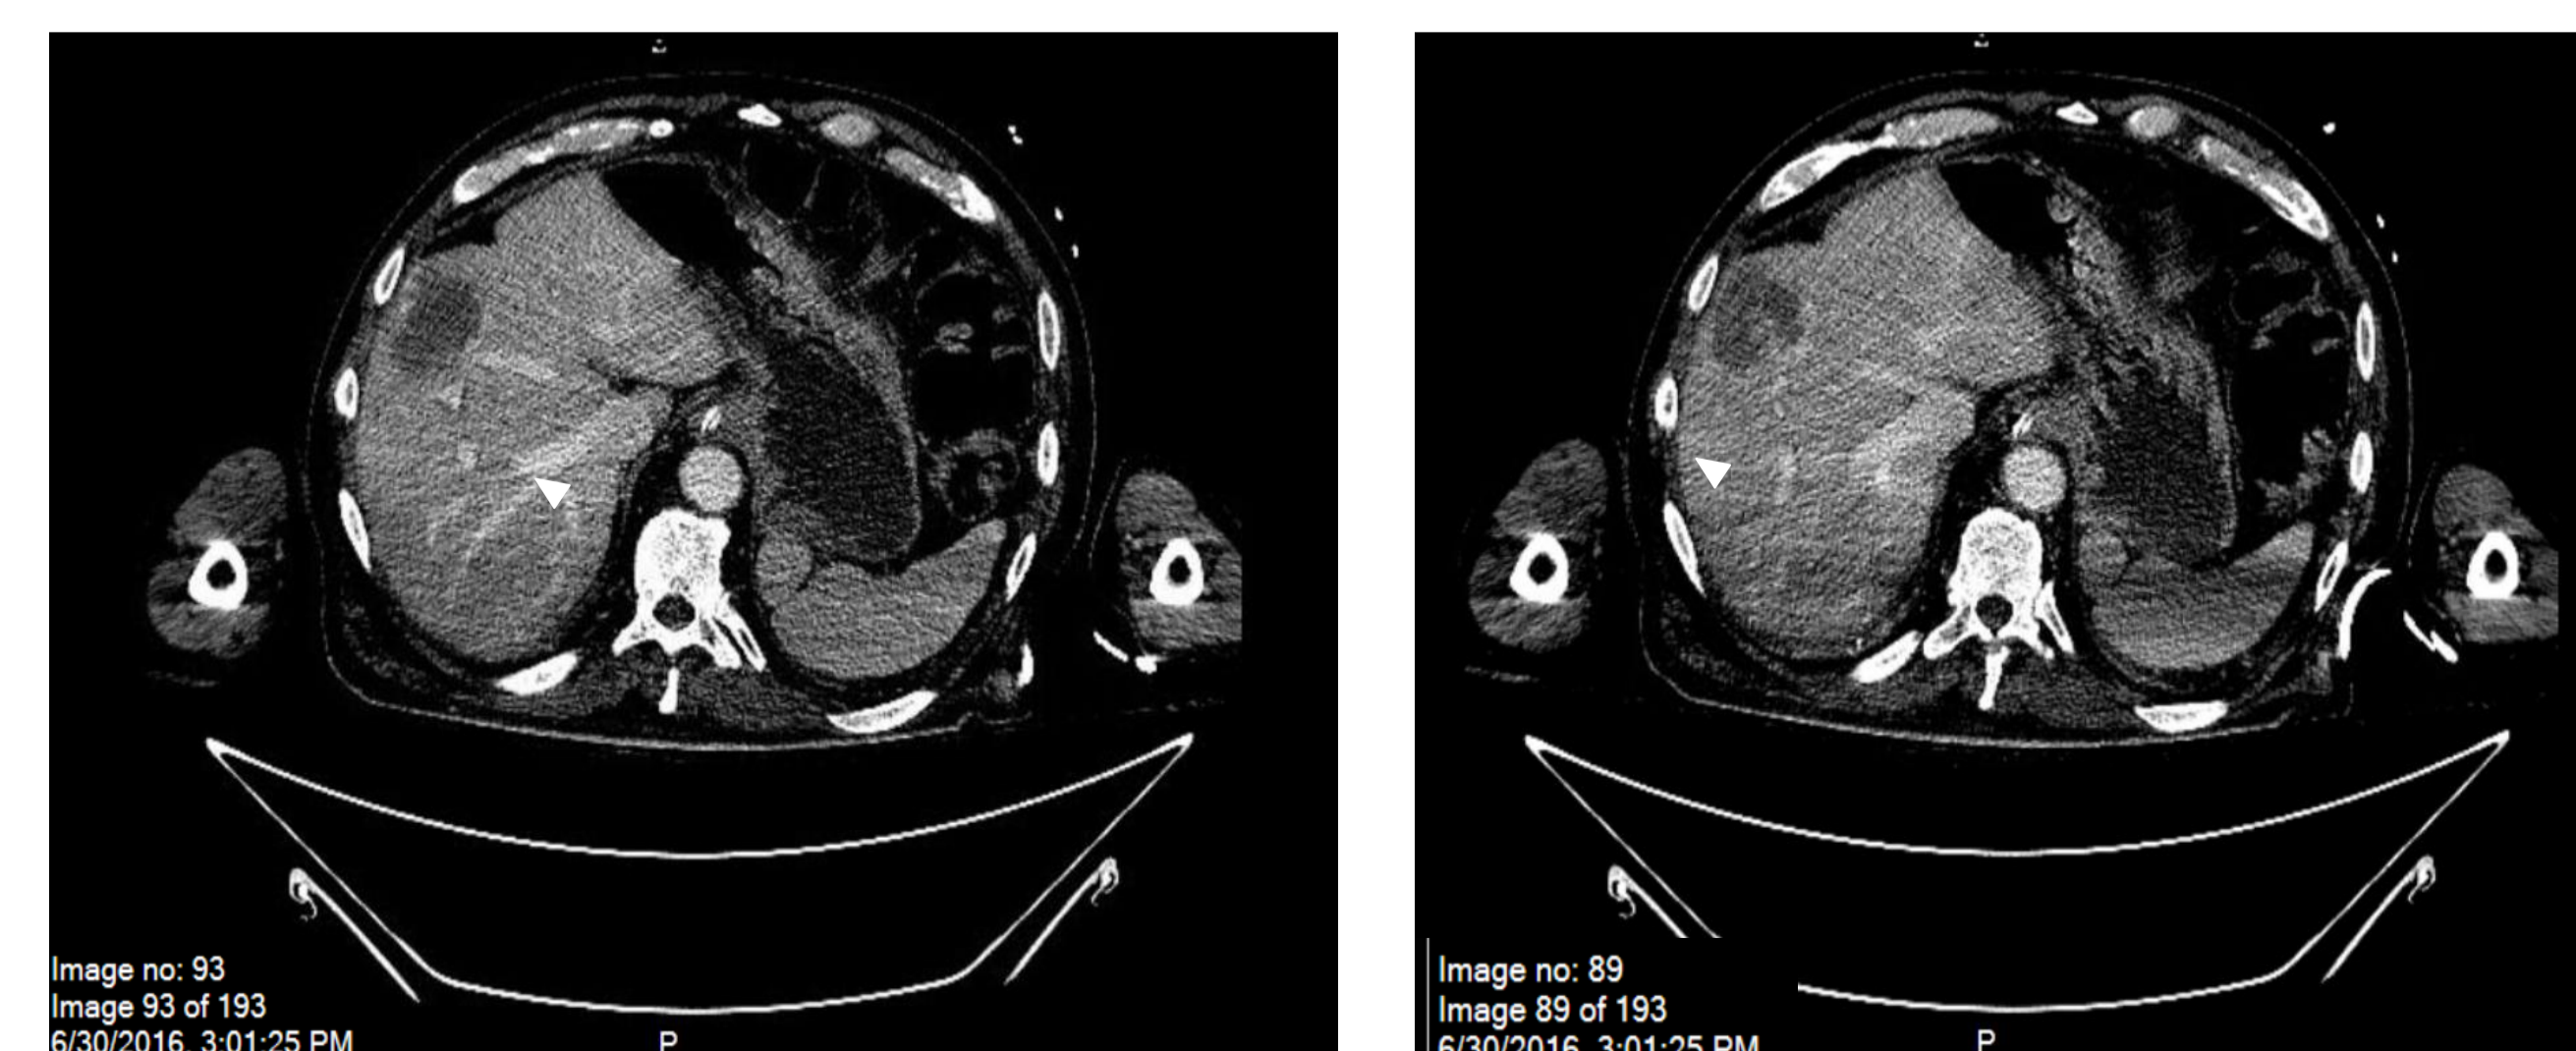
CT of abdomen shows a 5.2 x 5.2 cm heterogeneously enhancing lesion in the segment 8/4 A of the liver, few other hypodense lesions in the right lobe of the liver, changes likely related to metastasis. White arrow heads indicate the lesion.
